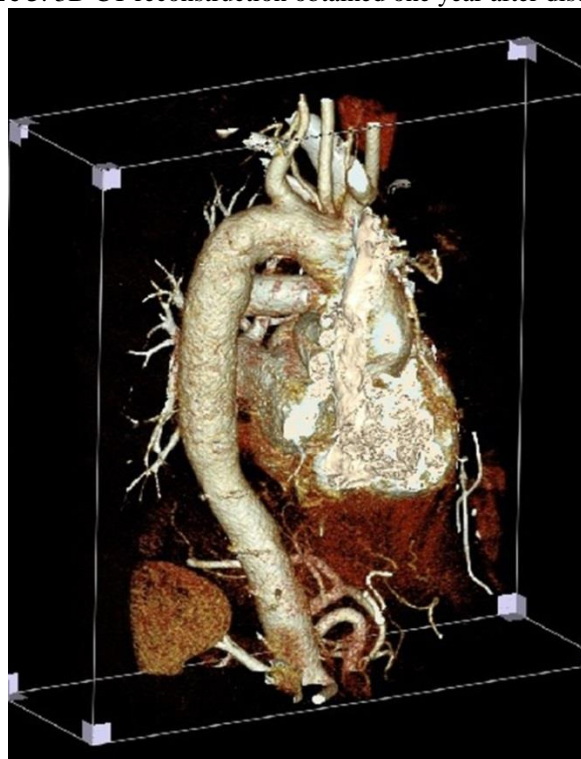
3D CT reconstruction obtained one year after discharge.
